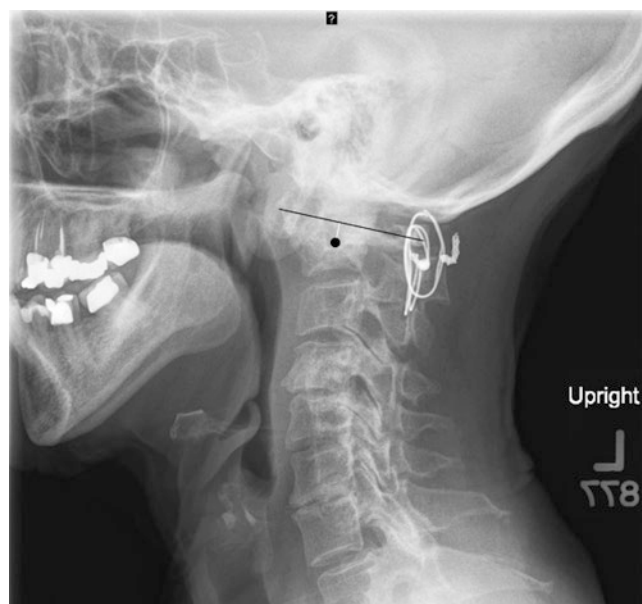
X-ray of cervical spine showing vertical atlanto-axial subluxation (AAS) with Ranawat’s method <9 mm
